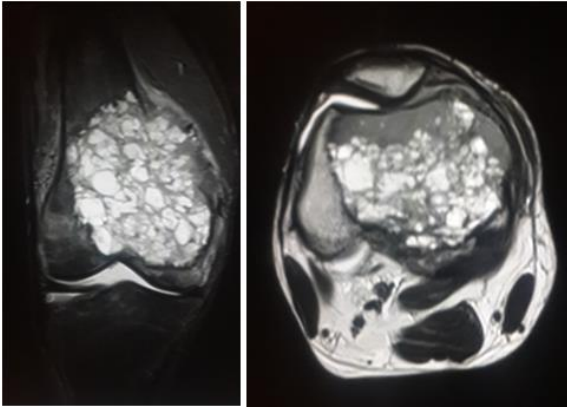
MRI of knee joint revealing hyperintense lesion with fluid filled levels with intra-articular extension.
